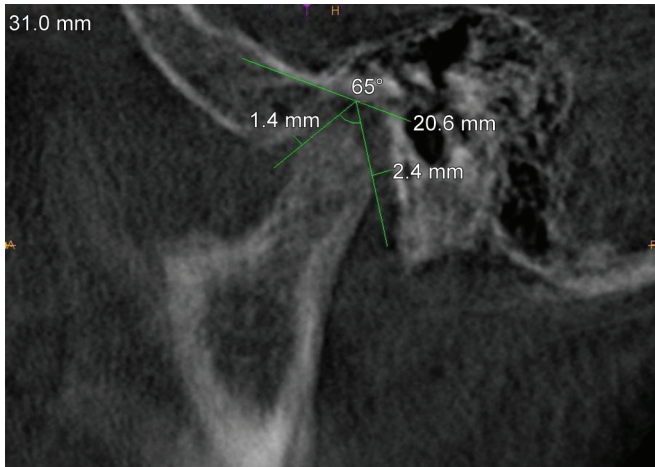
Cone-beam computed tomography (CBCT) scan of articular space anterior and posterior pretreatment
